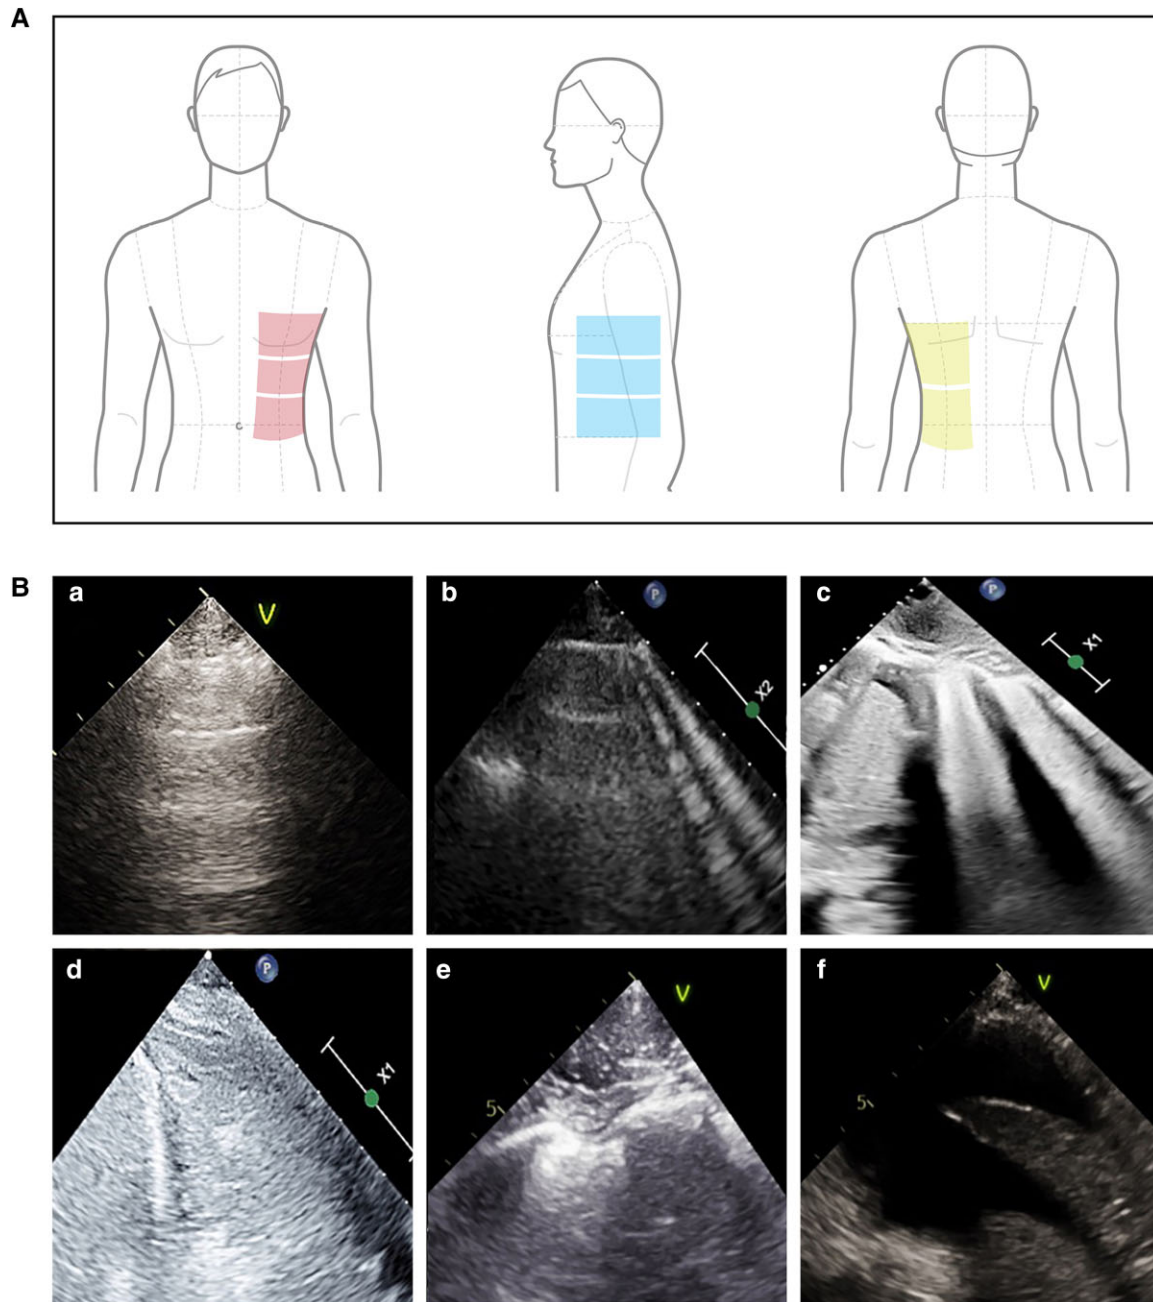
Lung ultrasound points and examples of different patterns of lung ultrasound findings. (A) Probe positions in the anterior and antero-lateral positions (left and middle), and in the postero-lateral positions (right). (B) The different patterns of US findings and scoring (a) A-lines, normal reverberation artifacts of the pleural line that correspond to normal aeration of the lung. Lung ultrasound score (LUS) equals zero. (b) Separated two fine B-lines that represent reverberation artefact through mildly oedematous interlobular septa or alveoli that correspond to moderate aeration lost. LUS score equals one. (c) Multiple coalescent B-lines that correspond to severe lung aeration loss. LUS score equals two. (d) Lung consolidation (liver is on the left side of the picture, the consolidated lung on the right, and between them the dense line of the diaphragm) that correspond to complete aeration loss. LUS score equals three (e) Patchy pleural thickening. Compare to the fine plural line in picture a. (f) Pleural effusion with lower lobe passive lung atelectasis within.
